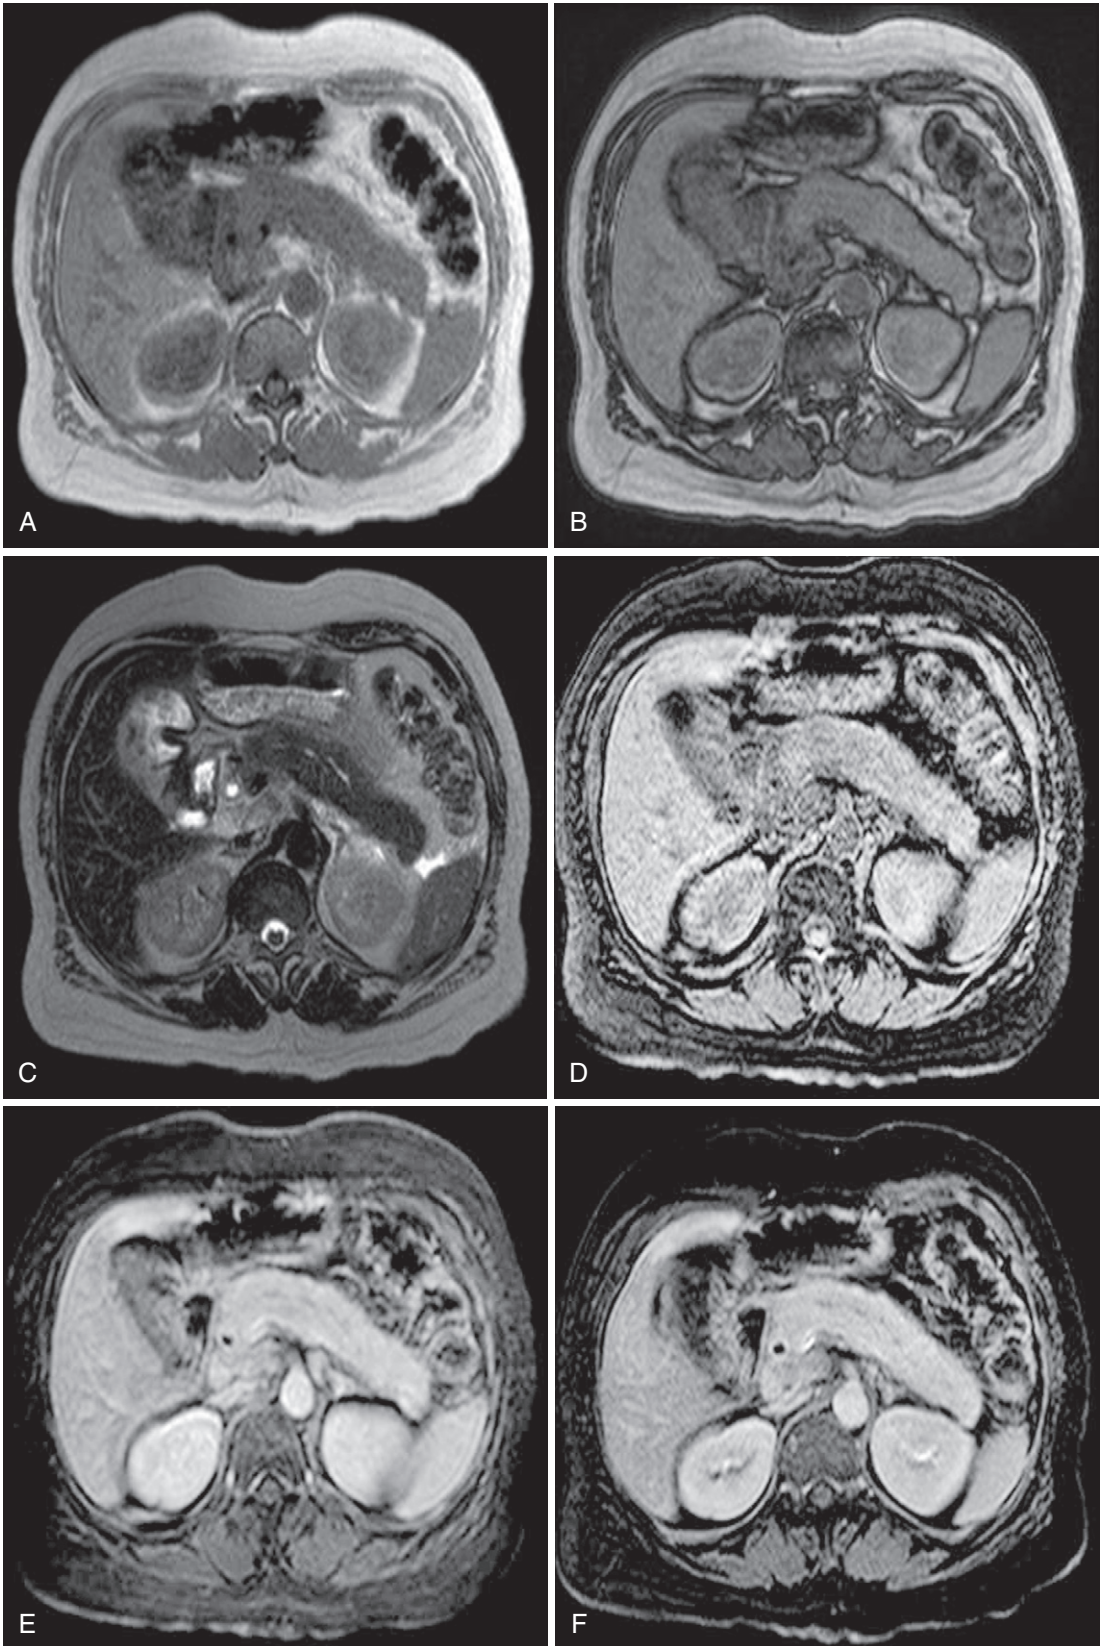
Autoimmune pancreatitis. In-phase (A) and out-of-phase (B) T1-weighted and T2-weighted (C) images of the pancreas demonstrate decreased T1-weighted signal intensity, a smooth contour, and focal duct dilatation in a patient with autoimmune pancreatitis. Precontrast (D), arterial (E), and delayed (F) fat-suppressed T1-weighted gradient recalled-echo images of the same patient demonstrate delayed pancreatic parenchymal enhancement.
